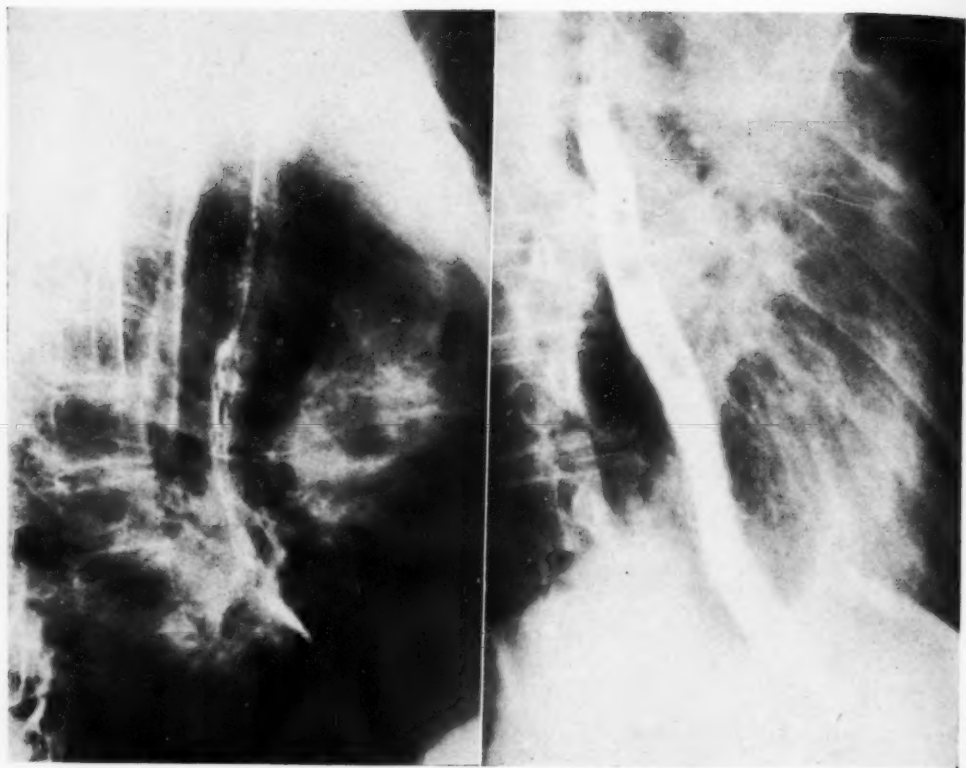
Case 2: Roentgenograms made Feb. 17, 1942.
